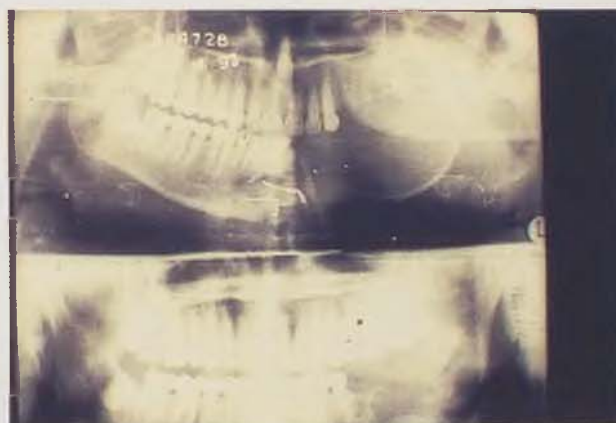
Pre and postoperative orthopantomograms.
